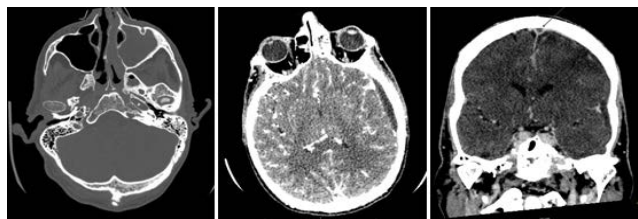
Preoperative axial and coronal CT-Scan (case 1) shows an extended left-sided pansinusitis with subdural empyema of left convexity and thrombosis of the superior sagittal sinus (black arrow).
